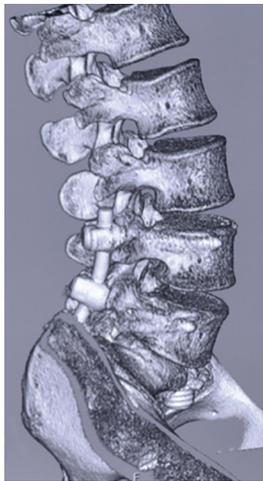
Postoperative 3D reconstruction CT image with implant *in situ*
